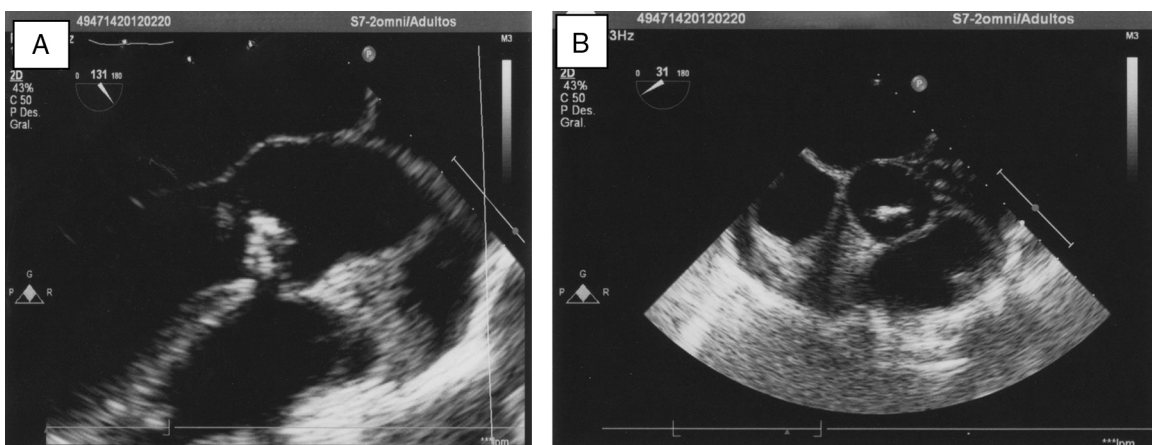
(A and B) Transthoracic echocardiography. The image shows the vegetation on the partially calcified bicuspid aortic valve, which appears with a partial prolapse and severe regurgitation. There is no evidence of heart failure.
